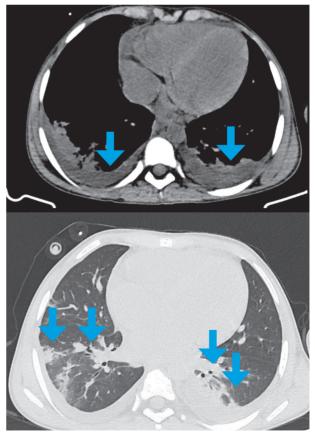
Patient chest computed tomography shows bilateral pleural effusion and pericardial effusion (A), bilateral pulmonary parenchymal ground-glass, and consolidative pulmonary opacities with atelectasis and air bronchogram with peripheral lung distribution on both lower lobes (B).
